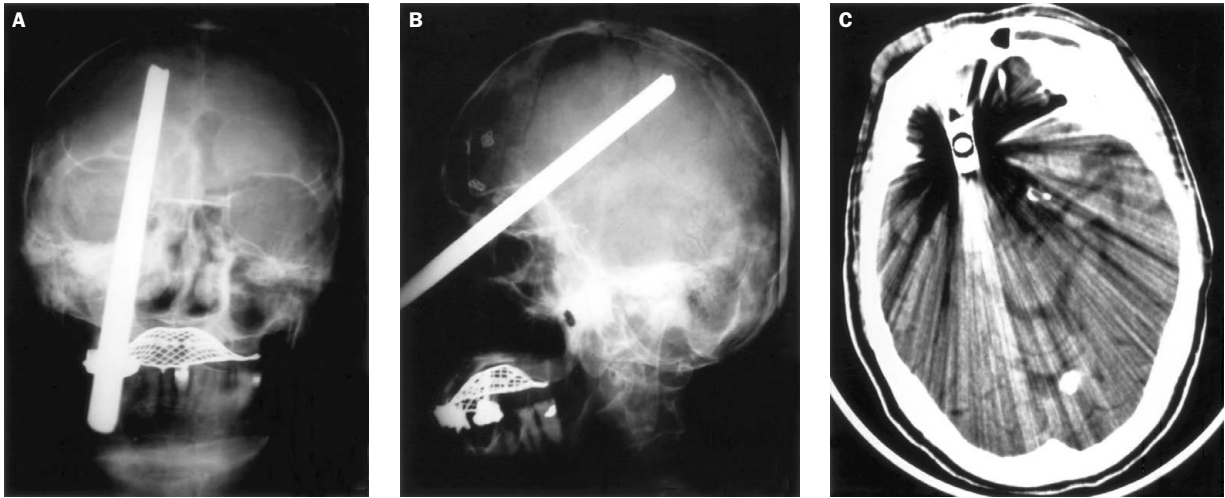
Skull X-rays of case 1 show that the skull is penetrated by a metal bar through the medial canthus of the right eye and through the orbital roof into the skull vertex: (A) anteroposterior view; (B) lateral view. (C) Computed tomography reveals marked artifacts but visible basal cisterns.
